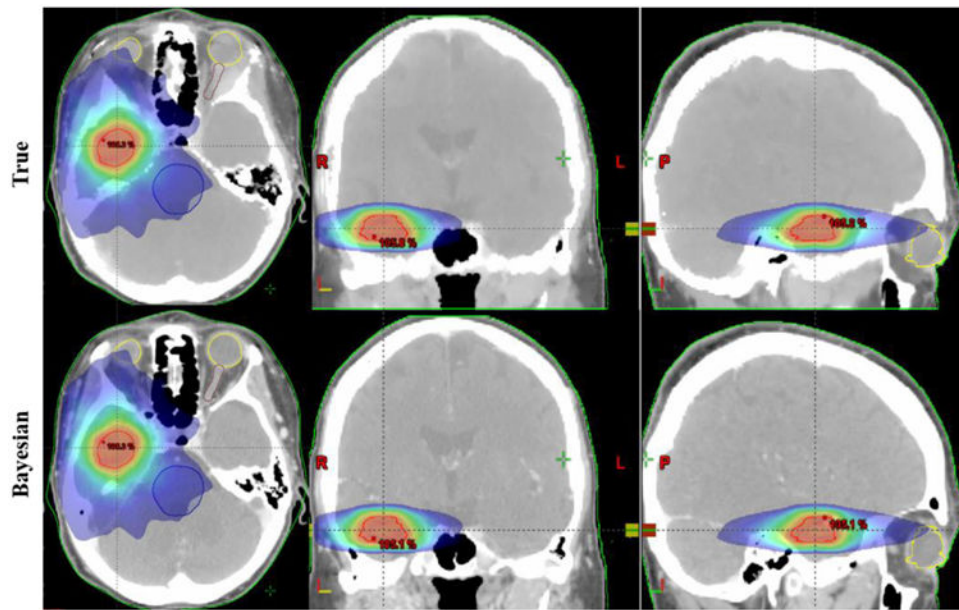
3D dose distributions in the axial, coronal and sagittal views, calculated based on the same treatment plan, using real CT and synthetic CT derived from the Bayesian approach.
